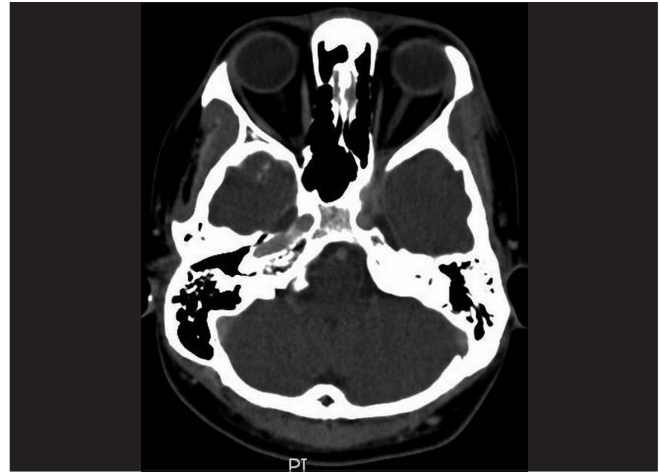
Computed tomography scan at 6 days posttreatment showing regression of the orbital lesion
